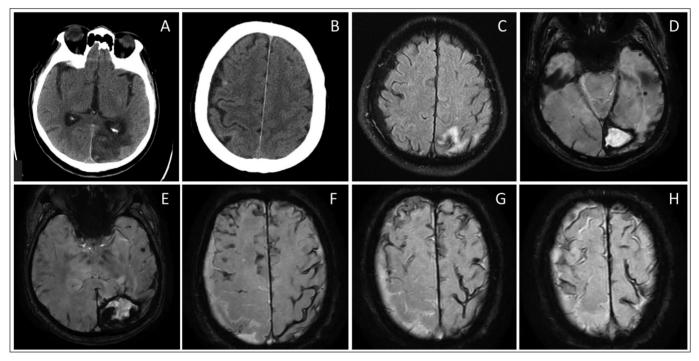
A patient, 80 years old, came for a consultation accompanied by his relatives, with complaints of decreased memory. Two months before, he suffered a stroke with the development of lobar intracerebral hematoma in the left parietal-occipital region. The patient was treated in the stroke department. During the examination in hospital, an atrial fibrillation was first detected, but due to the acute period of hemor-rhage, antithrombotic therapy was not prescribed. On CT scans of the brain, cystic-atrophic changes in the left parietal and occipital lobes were visualized (A), as well as the focus of the convexal subarachnoid hemorrhage in the right parietal lobe (B). Brain MRI (SWAN) allowed to additionally determine strictly lobar cerebral microbleeds (D,E) and disseminated cortical superficial siderosis (F,G,H), not accompanied by hyperintensity on the FLAIR (C) Based on the modified Boston criteria, probable cerebral amyloid angiopathy was suggested. The hemorrhagic phenotype of the disease with dissemination of cortical superficial siderosis and the presence of lobar hematoma in the anamnesis determined absolute contraindications for the oral anticoagulants, therefore, left atrial appendage occlusion (LAAO) was recommended as a measure of preventing thromboembolic events.*
